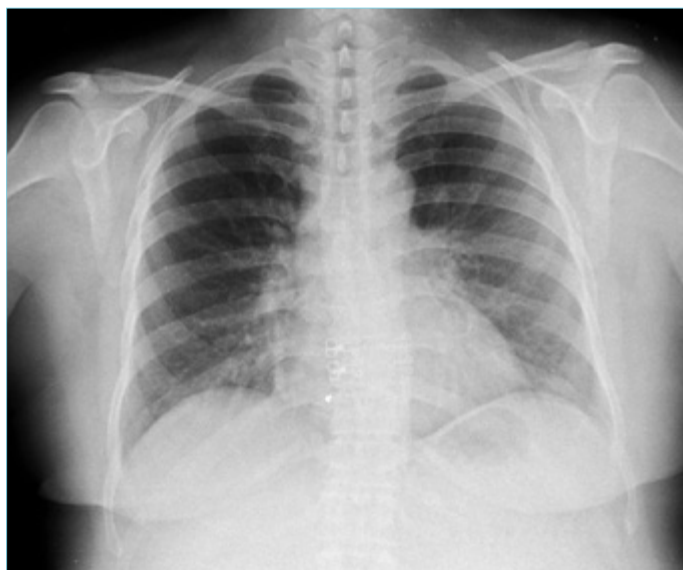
Image suggesting pulmonary edema in the PA chest X-ray taken at admission
